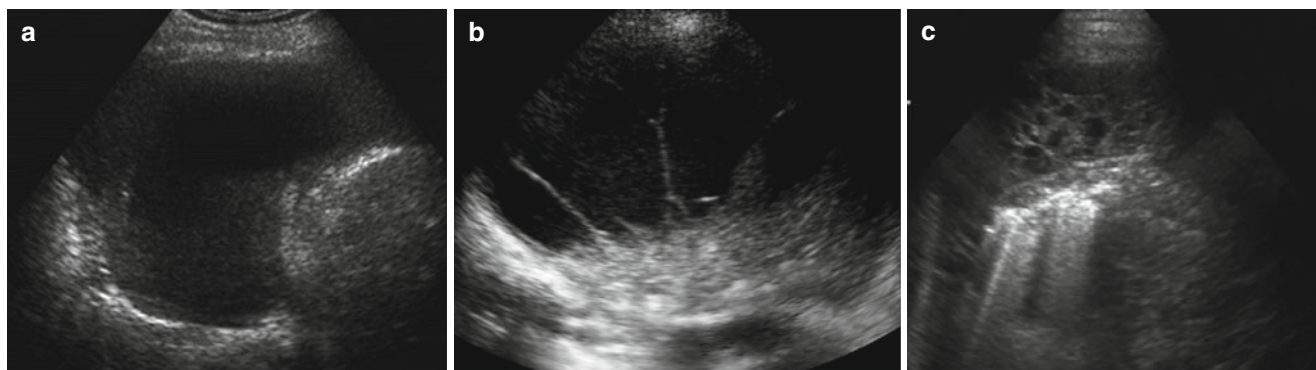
Parapneumonic fluid collections on ultrasound. Simple effusion showing anechoic fluid without septations (a). Complicated fluid collection with thin septations and proteinaceous debris (b).
